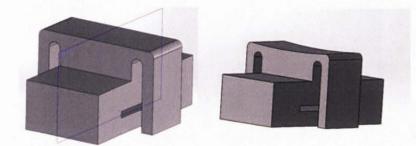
Second design of ultrasound holder. This design includes a slit for Velcro, and two arms to attach an elastic band, which keeps the ultrasound on the holder. The image on the right is the same design just with a slight curve to better hold the ultrasound.
